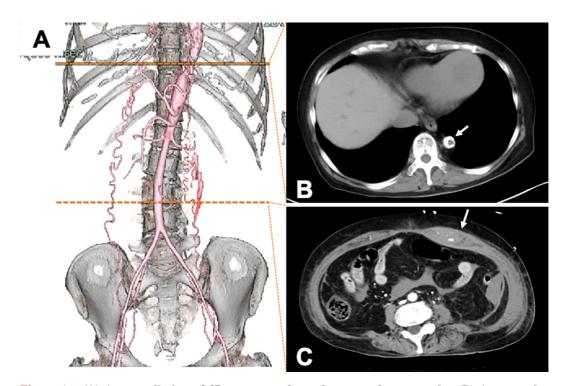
(A) An overall view of 3D contrast-enhanced computed tomography. (B) Aorta at the level of stenosis with a luminal diameter of 6 mm and an external diameter of 15 mm (arrow). (C) Aorta distal of the dilated and ruptured left epigastric artery (arrow).
